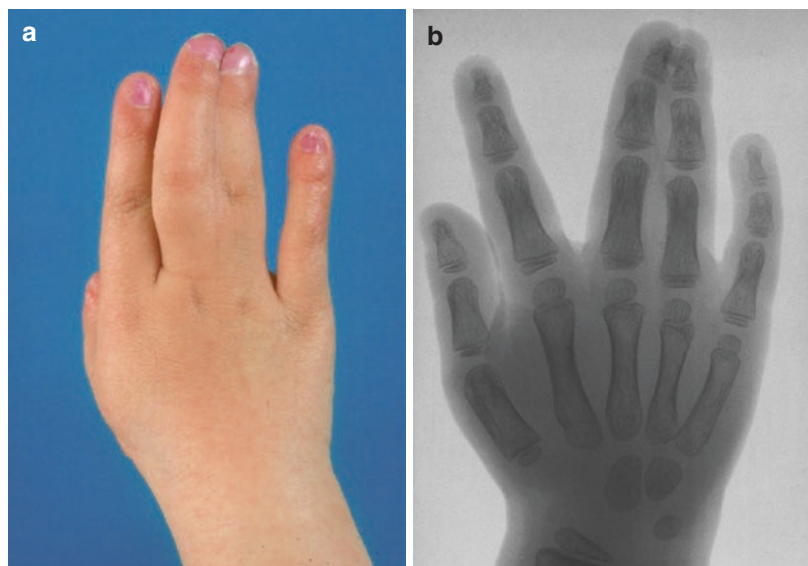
(a) Complete syndactyly of middle and ring finger. (b) The X-ray shows that this is a simple type in which only the soft tissues are involved
